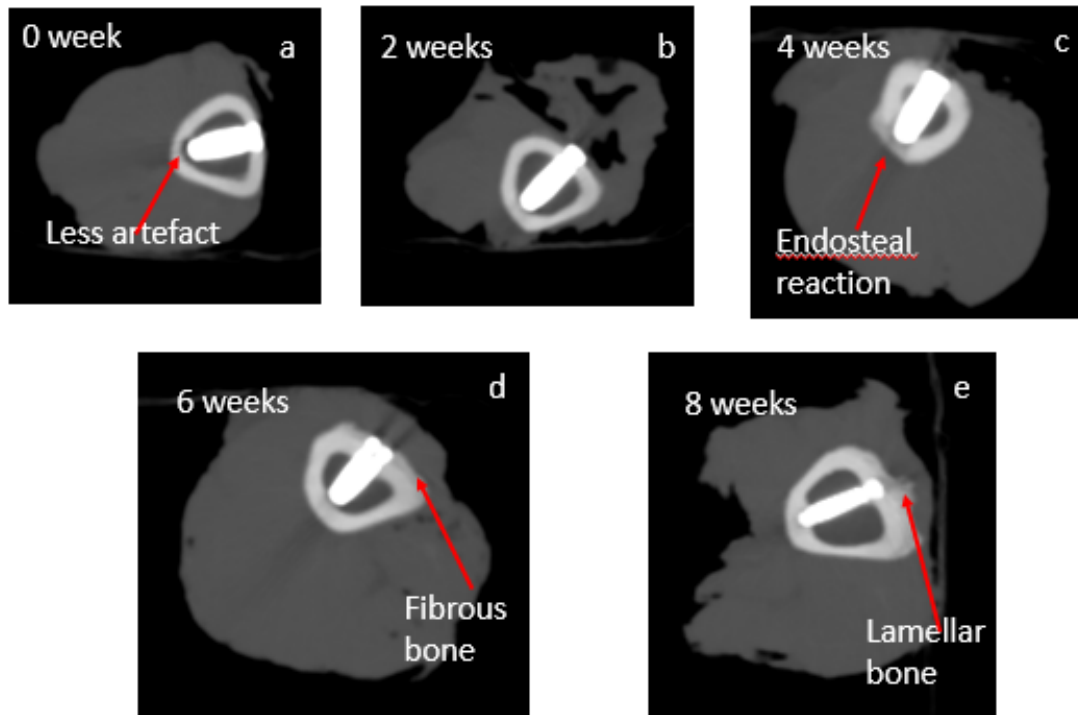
Dual energy CT images showing bone healing at the bone-metal interface with reduced artefacts and better contrast compared to single energy CT.
